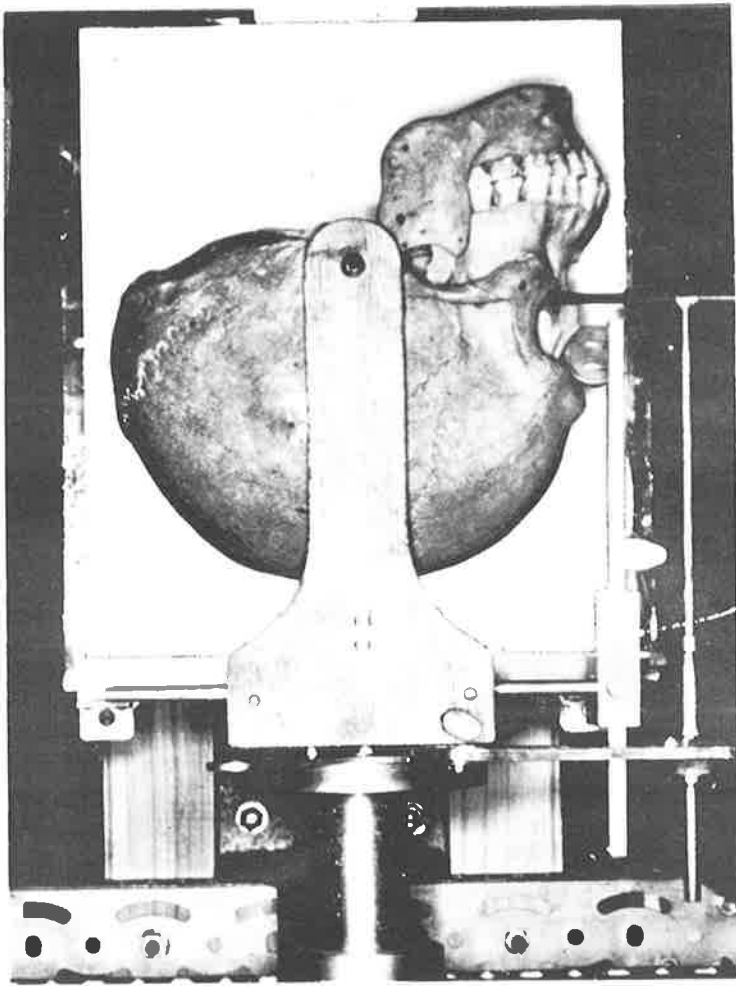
Method of skull positioning for roentgenography.
